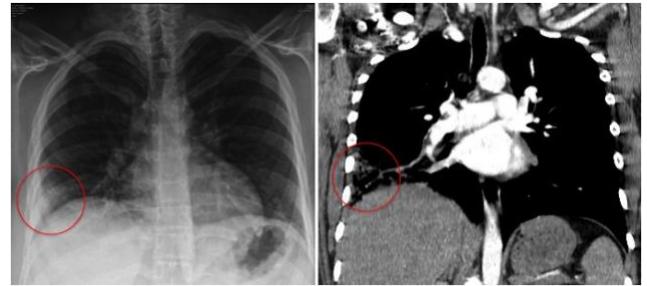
(a) CXR reveals Hampton's hump sign (red circle) (b) Chest CT angiography (coronal section) shows a filling defect in right lower lobe segmental branch complicated by wedge-shaped infarction (red circle) along right and diaphragmatic surface of pleura.
